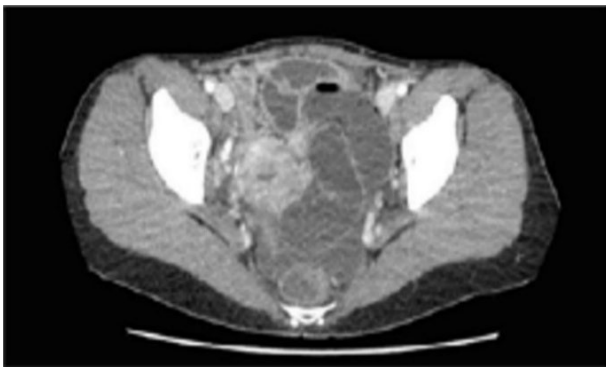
CT scan axial section in the early arterial phase demonstrates the majority of the occlusion located in the left hemipelvis, displacing the uterus to the right and ventrally, consistent with a left broadband hernia. [3].
